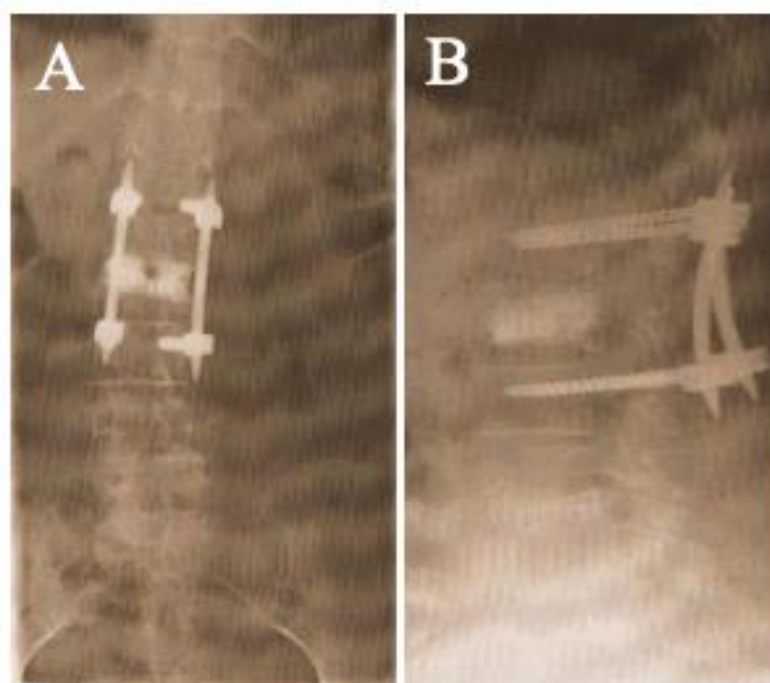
Case 5. (A) Plain x-ray a-p and (B) lateral views after 2 years of percutaneous stabilization and kyphoplasty showing reduction of the fracture without kyphosis.
